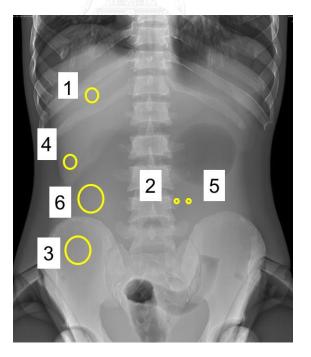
ROIs on the radiographic image for evaluating CNR.
